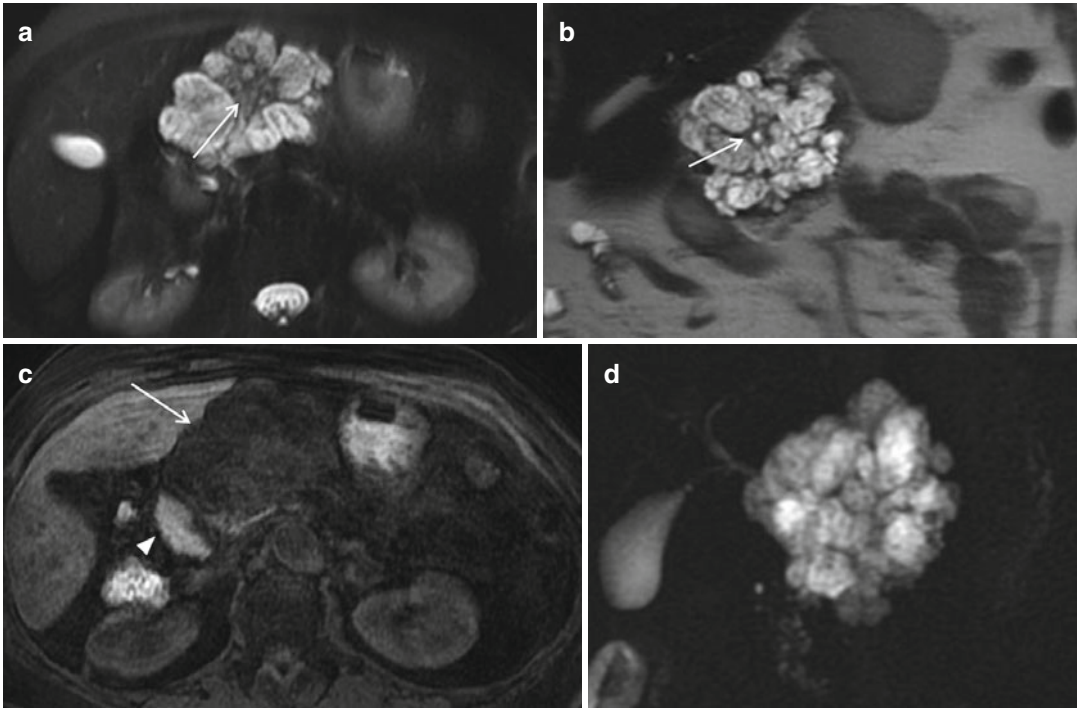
A 69-year-old female patient with serous cystadenoma in the pancreatic head. (a, b) Axial (a) and coronal (b) T2-weighted images: the lesion presents multiple hyperintense microcysts, with septa that radiate from the central scar (arrow). (c) Axial T1-weighted GRE image
